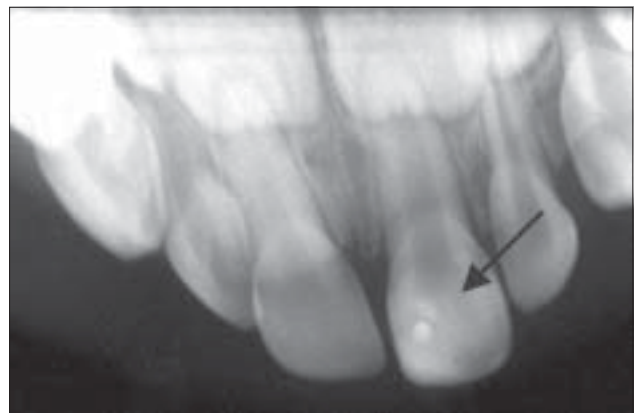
Three-month follow-up radiograph showing the development of a dentin bridge at the site of the partial pulpotomy.
